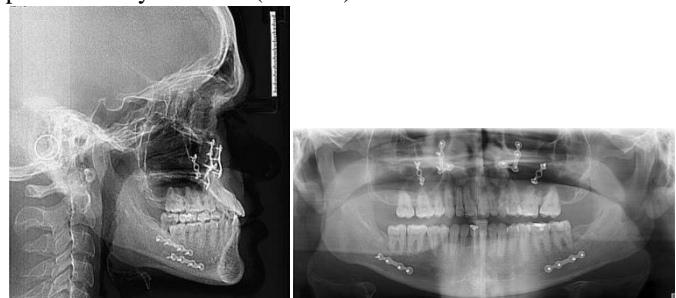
(a) Post-treatment lateral cephalogram and (b) Post-treatment orthopantomogram
